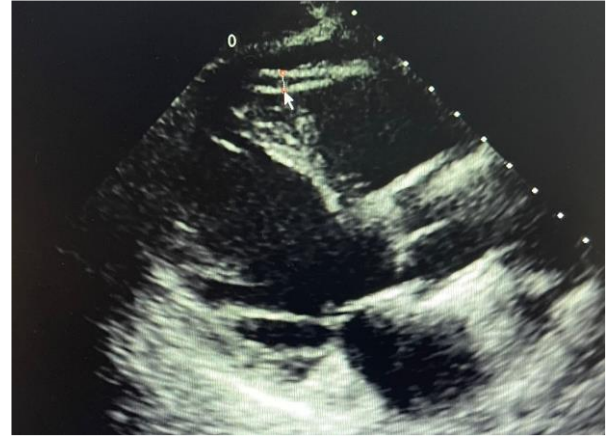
Long-axis parasternal view from transthoracic echocardiogram showing the epicardial fat over the free wall of the right ventricle
